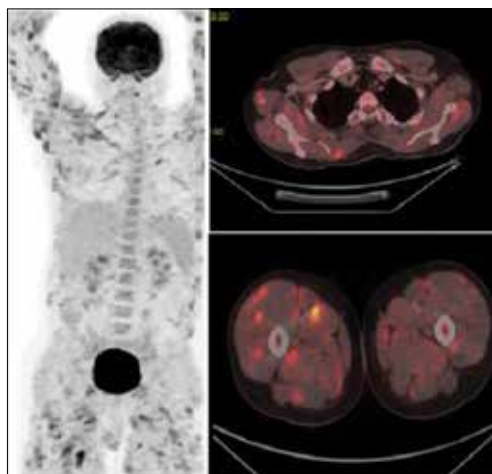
Positron emission tomography-computed tomography showing multiple minimally enhancing lesions in the muscles of body
